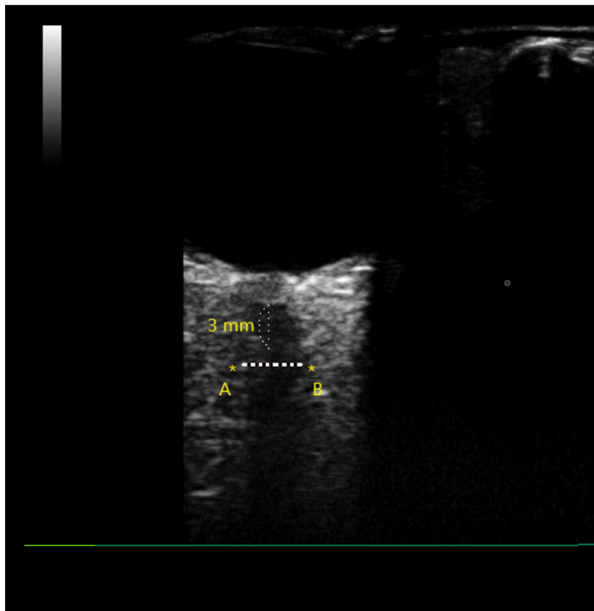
Measurement of optic nerve sheath diameter (ONSD) by ultrasonography. Axial images of the orbit were acquired in the plane of the optic nerve. ONSDs were measured 3 mm posterior to the optic nerve head (A-B).
